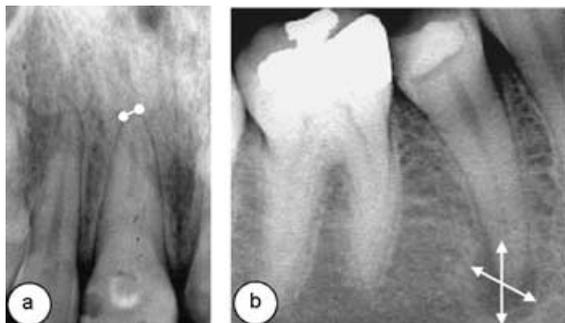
Determination of radiographic bone lesion size (a) small and (b) large.
